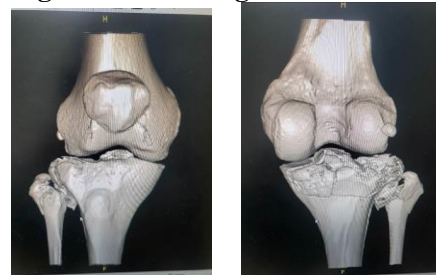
CT of right knee
